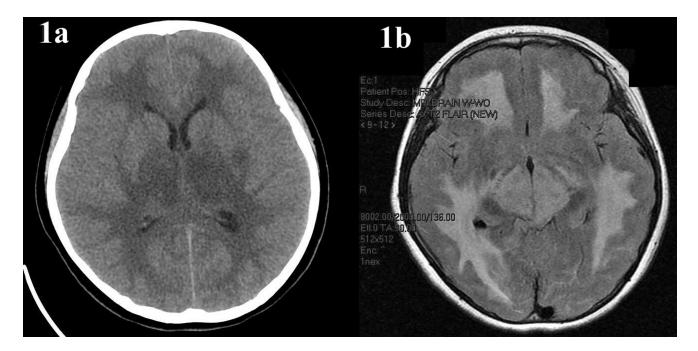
a,* Noncontrast head computed tomography scan reveals extensive hypodensity in the white matter as well as the basal ganglia and thalami consistent with global insult. In addition, there is generalized cerebral edema. *b,* Magnetic resonance imaging of the brain (with fluid attenuation inversion recovery) demonstrates extensive and diffuse white matter and subcortical white matter signal abnormality that includes the bilateral thalami as well as increasing cerebral edema.
